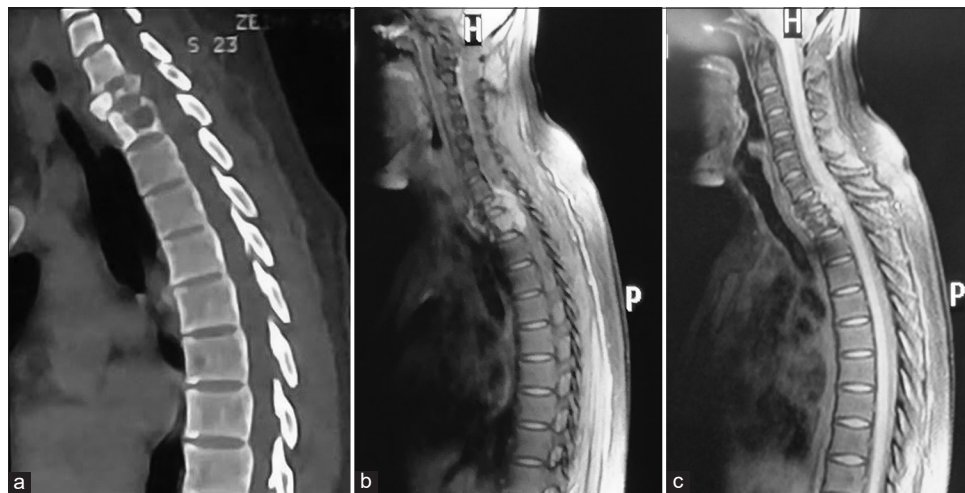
(a) Computerized axial tomography showing pathological fracture at D1 and D2 vertebrae. (b) T2 sequence with fat suppression of magnetic resonance imaging of the cervicothoracic spine showing neoplastic infiltration into D1 and D2 vertebrae, associated to epidural component generating spinal cord compression.
